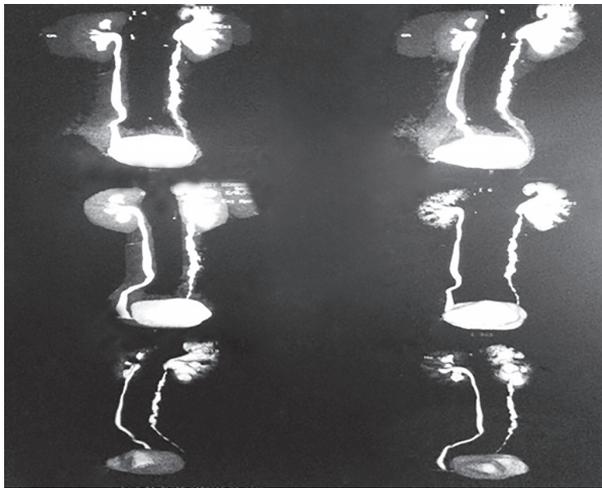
Computed tomography and intravenous urography showing diffuse wall thickening and luminal irregularity in entire left ureter with moderate luminal narrowing at pelvi-ureteric junction and diffuse narrowing of lower ureter. Left ureter is showing beaded appearance s/o panureteral stricture
